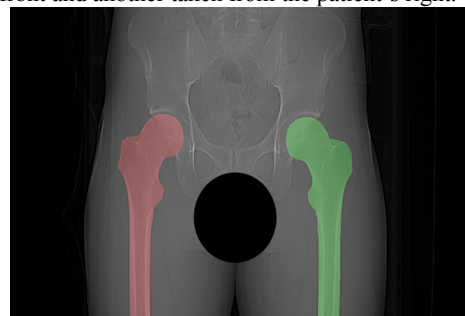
Segmented frontal radiograph. Pixels belonging to the patient's right/left femur are colored in red/green
